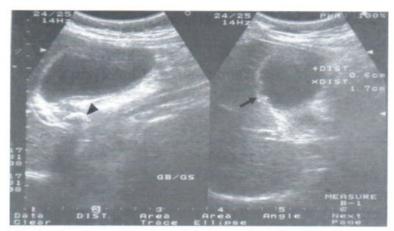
Acute uncomplicated cholecystitis. Ultrasound demonstrates distended gallbladder with thickened wall (arrow). There is a shadowing stone (arrowhead) in the gallbladder neck.
